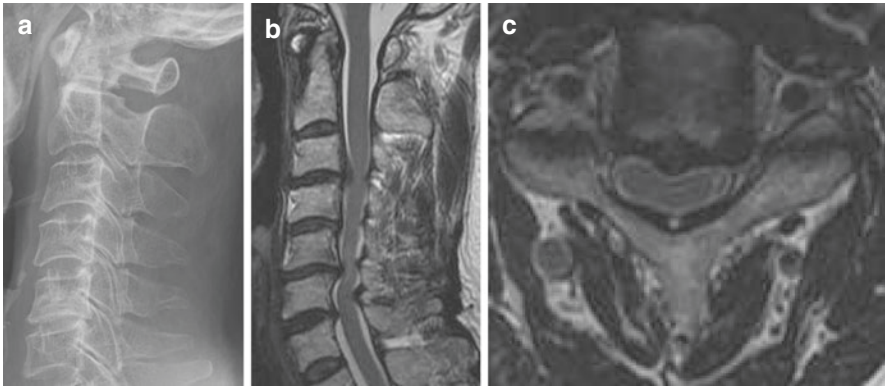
Cervical plain radiograph (a) and MRI (b and c) in a typical case of CSM
